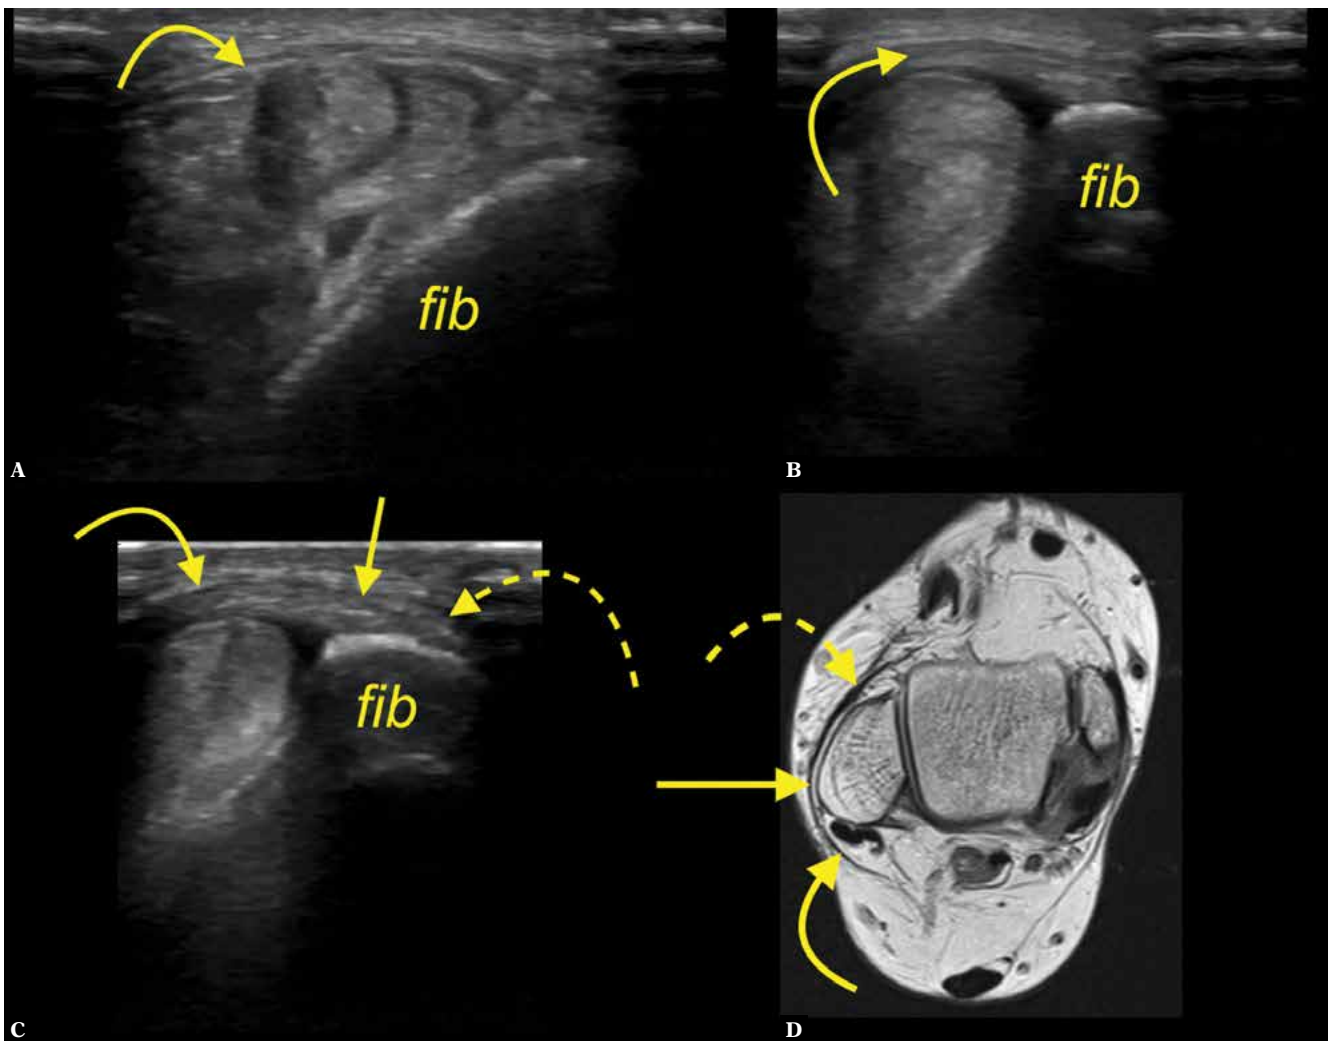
A 42-year-old patient presenting clinical suspicion of synovitis. A, B, C. transverse section on ultrasound, d. proton density-weighted oblique oriented section. The interconnection (arrows) between the SPR (curved arrow) and IER (dashed arrow); fib- fibula
